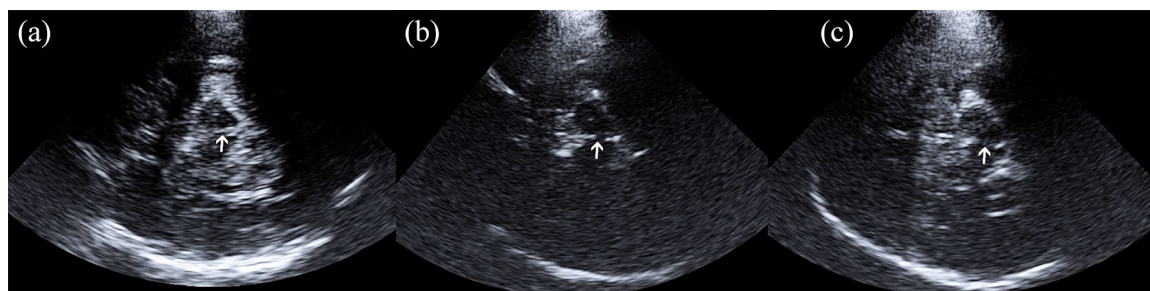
Examples of normal and hypoechogenic MBR on TCS. (a) Normal MBR on TCS image. The MBR is a clear and continuous line of high echogenicity (Grade 2; arrow). (b) Slightly reduced or interrupted echogenicity of the MBR on TCS image (Grade 1; arrow). (c) MBR with markedly reduced echogenicity on the TCS image, which is not visible despite the clear visibility of the red nuclei and basal cisterns (Grade 0; arrow). MBR, midbrain raphe; TCS, transcranial sonography.
